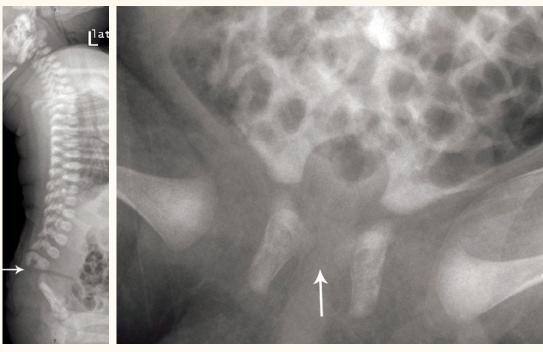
X-ray showing sacral agenesis with iliolumbar articulation Type III
